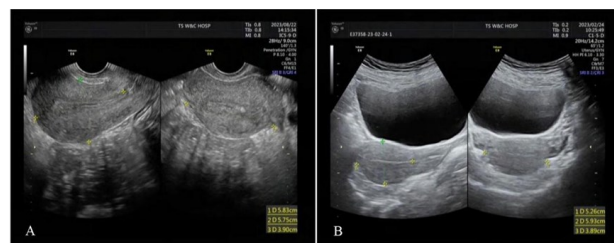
Representative images of (A) abdominal ultrasound examination and (B) transvaginal ultrasound examination for gynecological acute abdomen.
